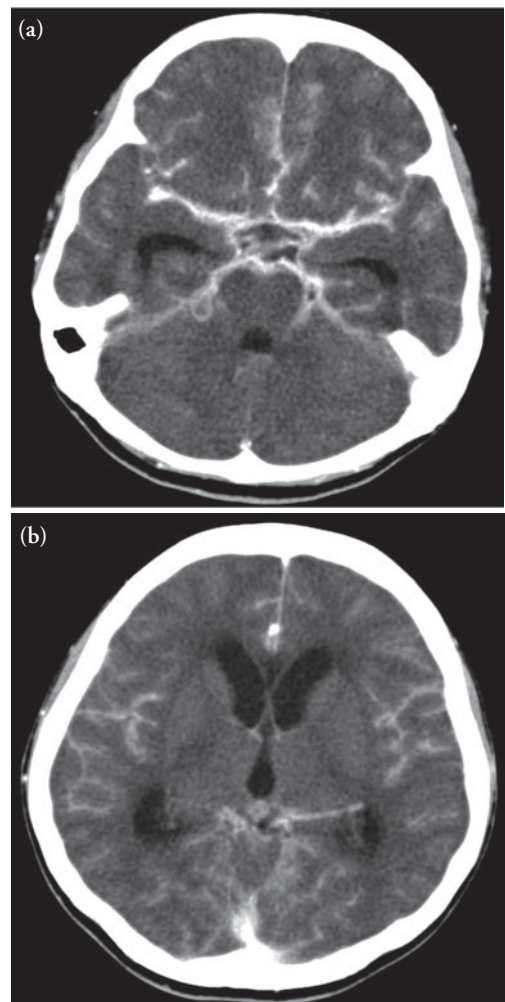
Post-contrast axial CT scan of brain at different levels.
